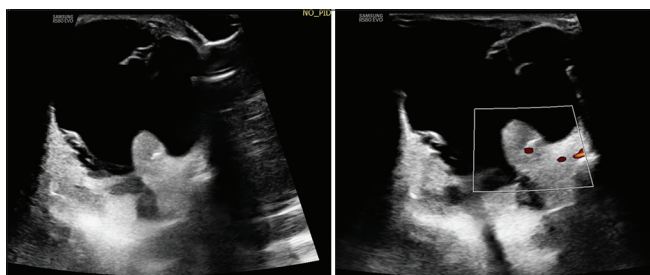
Sonographic image of the patient with color Doppler shows multiloculated cystic lesion with thin internal septation and eccentric solid area with focus of calcification, showing color flow on color Doppler imaging in superomedial compartment.
